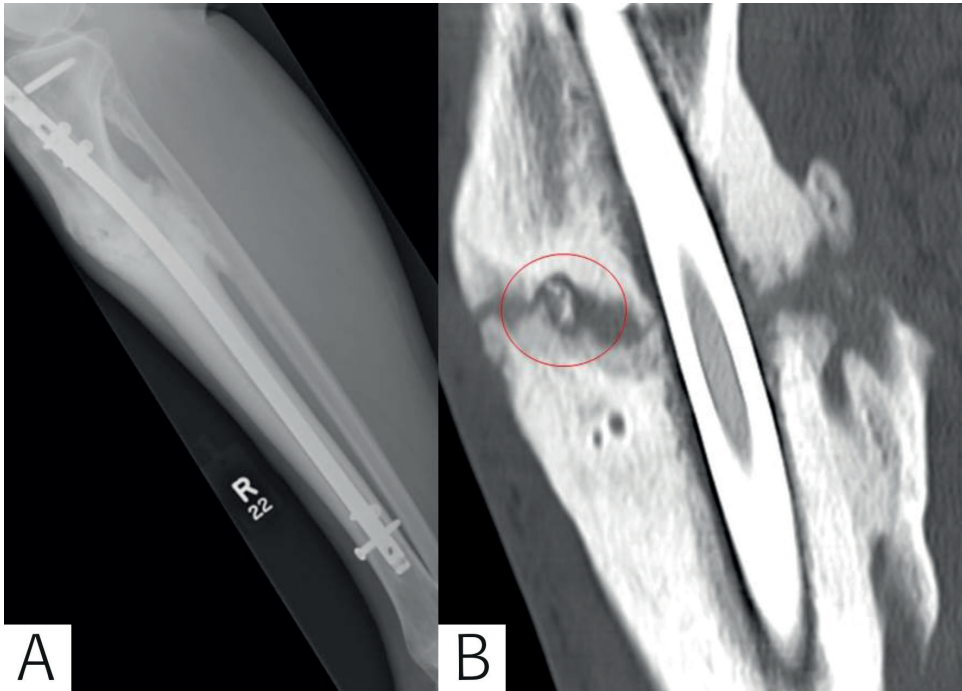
Example of an lateral X-ray (A) and sagittal CT-scan image (B) showing a small sequestrum in an infected non-union which was initially missed on plain x-ray. The patient had already had an exchange nail, without removing the sequestrum and got an immediate recurrence of the FRI.
